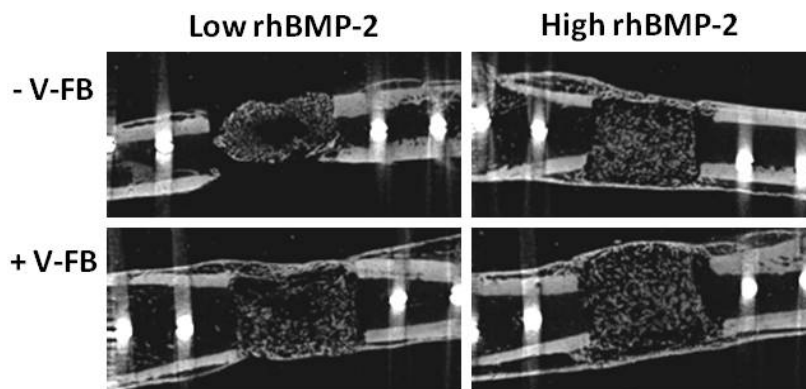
2 Representative  $\mu\text{CT}$  images at week 4 from the non-infected segmental defect study. PUR implants with both rhBMP-2 dosages were tested, with or without the presence of V-FB.
